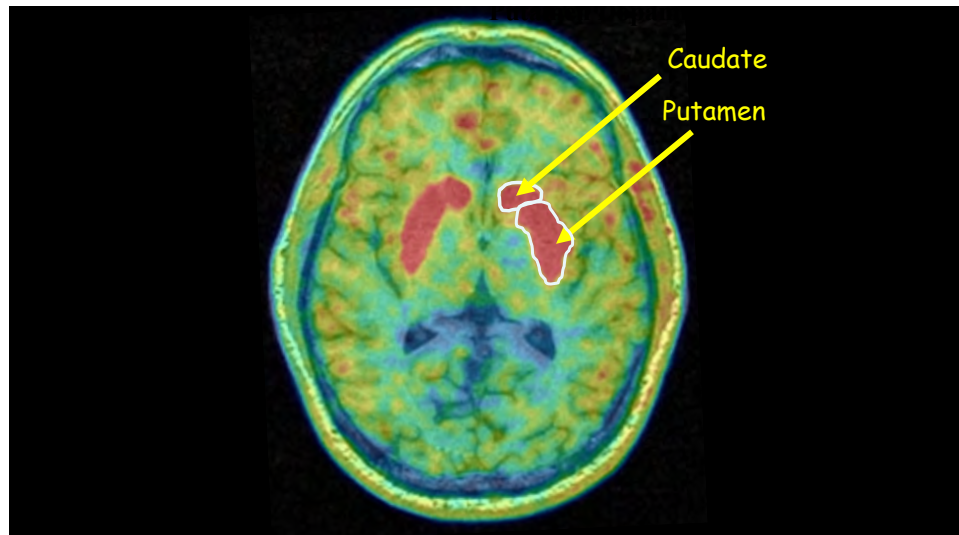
^{18}F -DOPA PET/MRI scan. The ^{18}F -DOPA PET image superimposed on the person's MRI scan shows the dopamine-containing terminals in the striatum (caudate and putamen). See the "sad clown's eyes?"
